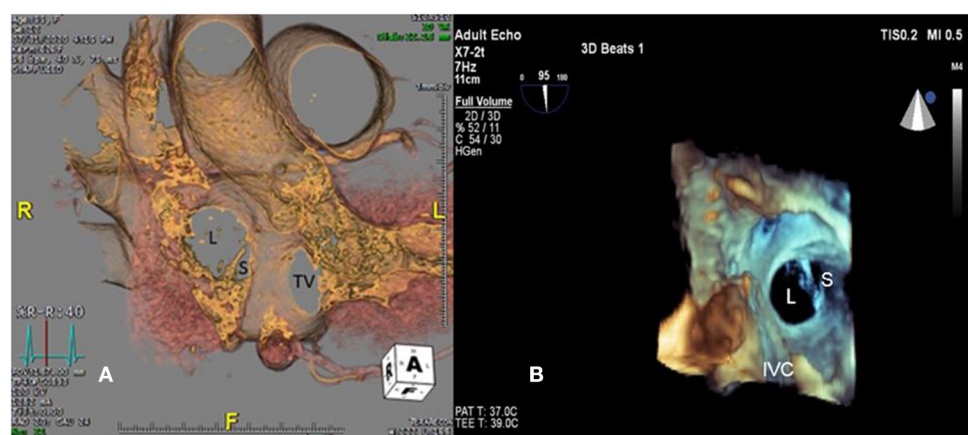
Large (L) and small (S) ASDs are revealed in (A) cardiac computed tomography and (B) three-dimensional transesophageal echocardiogram. TV, tricuspid valve.
